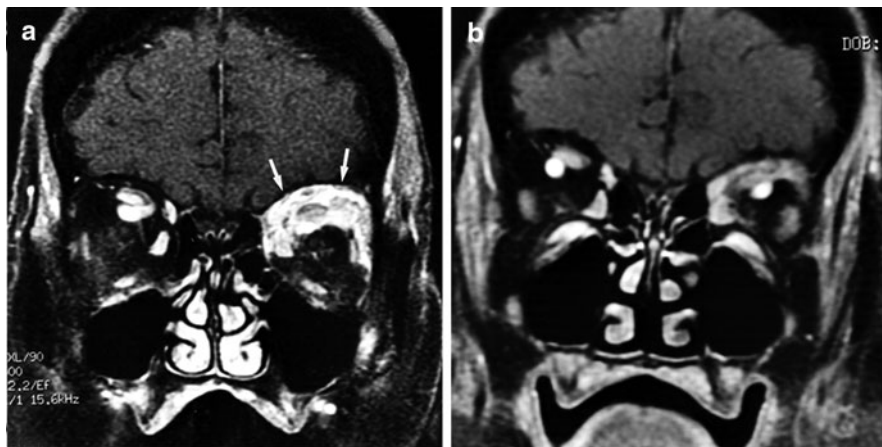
Magnetic resonance imaging of orbital lymphoma before (a) and after (b) radioimmunotherapy using ibritumomab tiuxetan (Zevalin)
